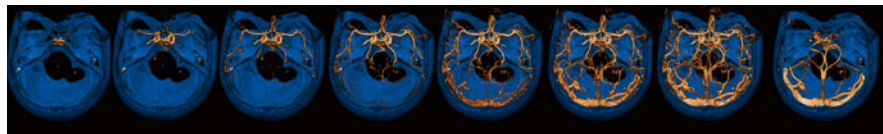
Fifty-four y/o female, presenting with right-sided motor and sensory deficit and aphasia for which she received i.v. rTPA. NECT, VPCT, and CTA were without abnormalities. Shown are the VR images from the 4D-CTA with bone suppression (*blue*) derived from the dynamic phases of the VPCT. Normal arterial and venous phases are demonstrated by this 4D-CTA
